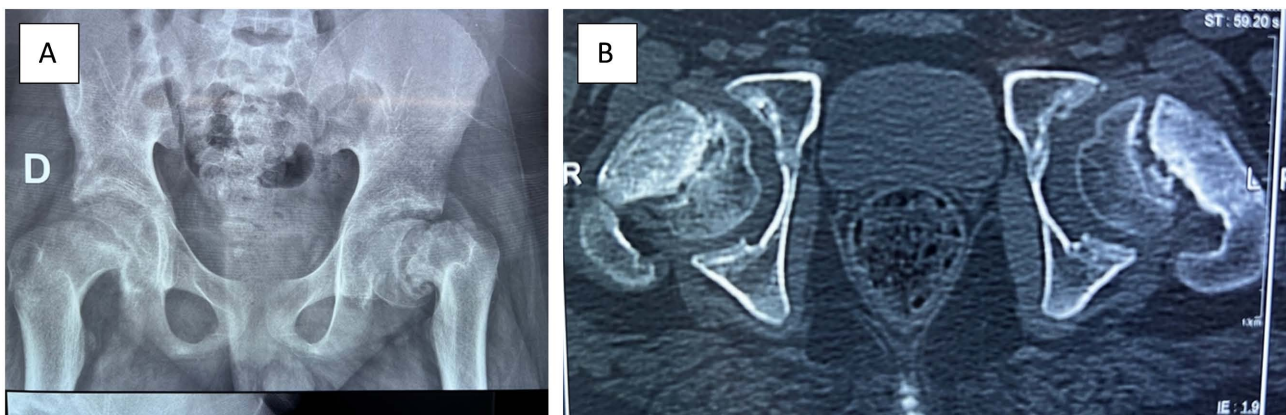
Imaging of a patient with bilateral slipped capital femoral epiphysis. (A) Standard anteroposterior pelvic radiograph. (B) Axial computed tomography scan of both hips demonstrating epiphyseal displacement.
